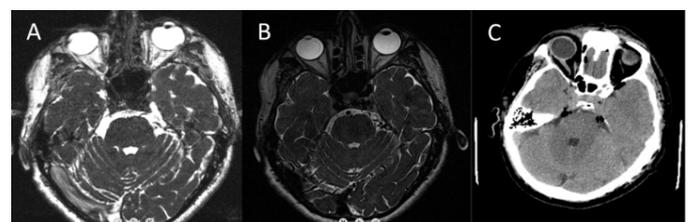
Preoperative T2-weighted CISS MRI (A-B) and postoperative CT (C) study of the patient.
